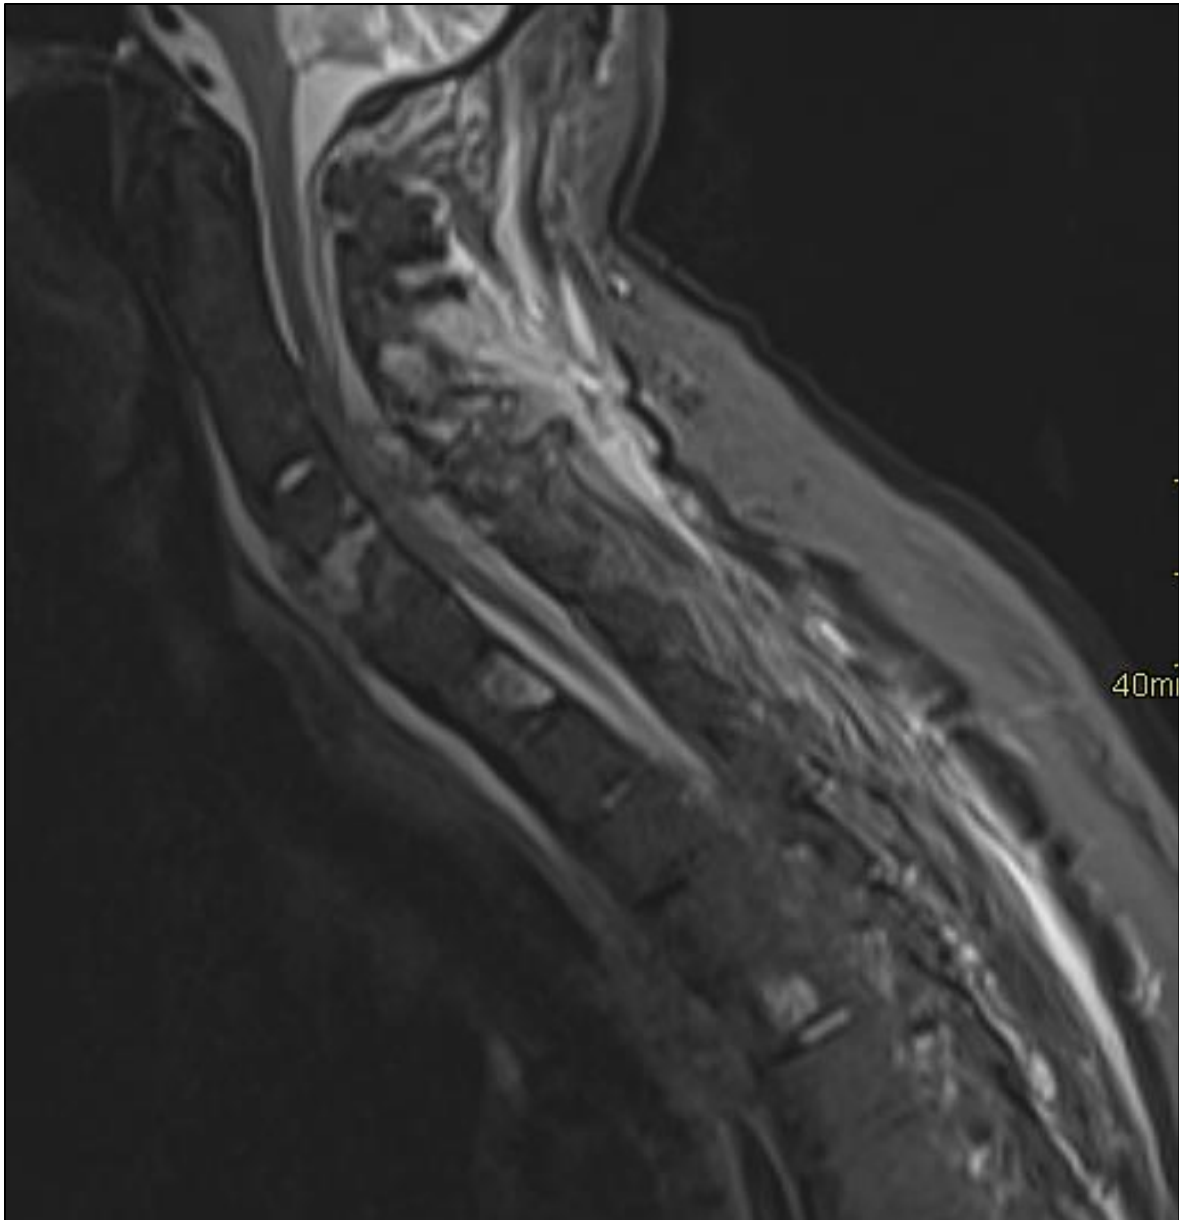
Fracture of the cervical spine in a patient with DISH. a. Sagittal reformatted CT showing a transdiscal fracture C5-C6 partially involving the vertebral body C6 (white arrow) extending into the posterior elements (spinous process, black arrow) in keeping with involvement of the 3 columns of Denis. b. Lateral radiograph with improper positioning due to spinal rigidity failed to detect the fracture. c. Sagittal fatsuppressed T2-weighted image confirms partially transdiscal fracture (white arrow) extending into the posterior elements with disruption of the anterior longitudinal, interspinous, and supraspinous ligaments. The fracture is open anteriorly. There is a large fluid cleft in the disc space C5-C6 with adjacent bone marrow edema in the vertebral body C6. Note a posterior epidural hematoma compressing the spinal cord. Incidental haemangiomas are seen at the vertebral bodies Th1 and Th5.
